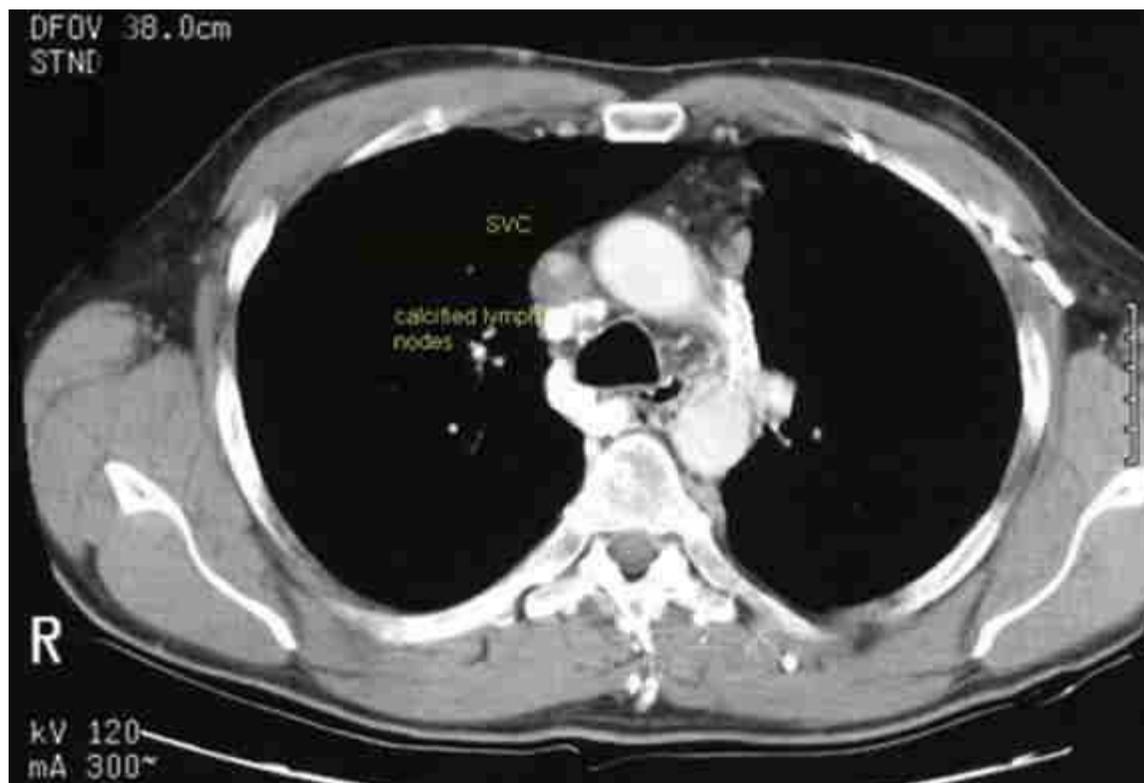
Superior vena cava syndrome (case 1). The patient was a 35-year-old man with a 3-year history of progressive upper-extremity and fascial swelling. The patient had undergone treatment for histoplasmosis in the past. CT scan shows a narrowed superior vena cava with adjacent calcified lymph nodes and posterior soft tissue thickening
